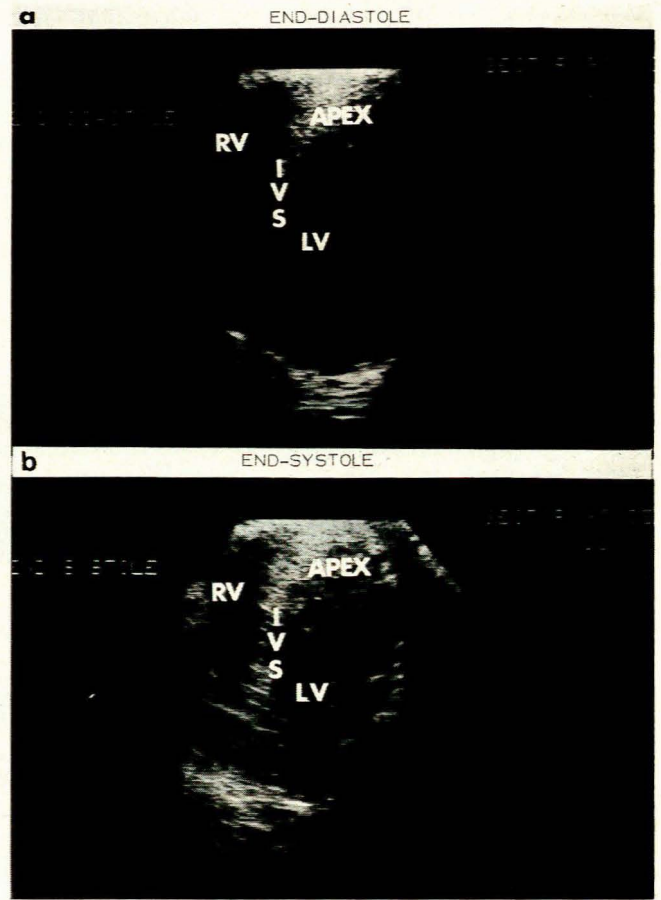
Short-axis two-chamber view two-dimensional (cross-sectional) echocardiogram in (a) end-diastole and (b) end-systole. Marked reduction of the left ventricular apical cavity is visualized at the end of systole.
